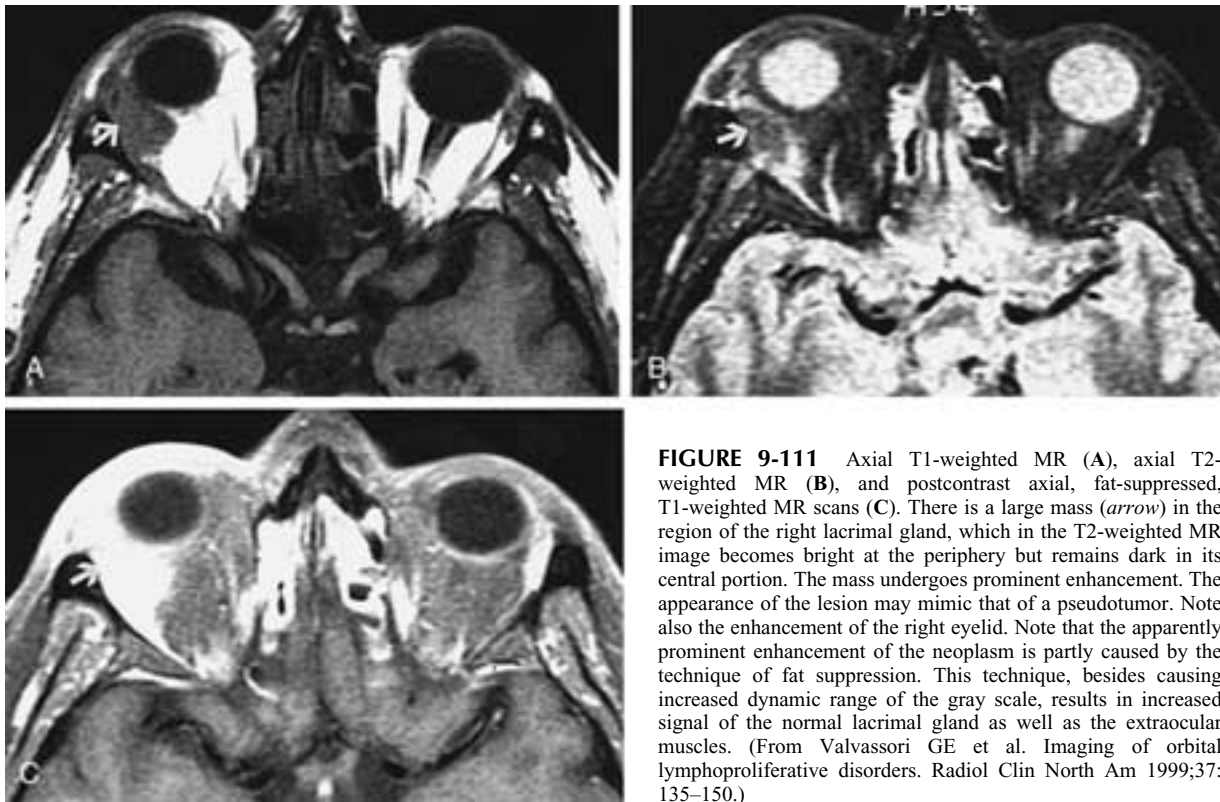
Axial T1-weighted MR (A), axial T2-weighted MR (B), and postcontrast axial, fat-suppressed, T1-weighted MR scans (C). There is a large mass (arrow) in the region of the right lacrimal gland, which in the T2-weighted MR image becomes bright at the periphery but remains dark in its central portion. The mass undergoes prominent enhancement. The appearance of the lesion may mimic that of a pseudotumor. Note also the enhancement of the right eyelid. Note that the apparently prominent enhancement of the neoplasm is partly caused by the technique of fat suppression. This technique, besides causing increased dynamic range of the gray scale, results in increased signal of the normal lacrimal gland as well as the extraocular muscles. (From Valvassori GE et al. Imaging of orbital lymphoproliferative disorders. *Radiol Clin North Am* 1999;37:135–150.)
